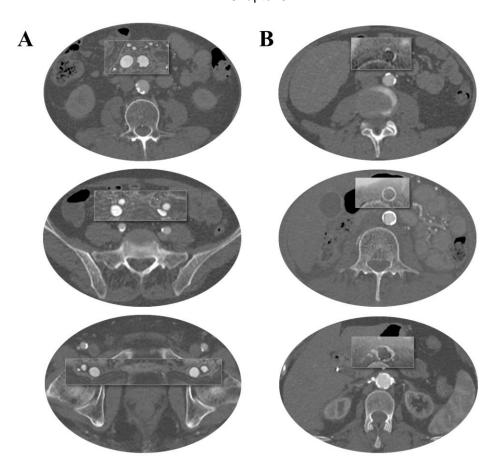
Transverse views of CTA, FeMRA and StarVIBE.
